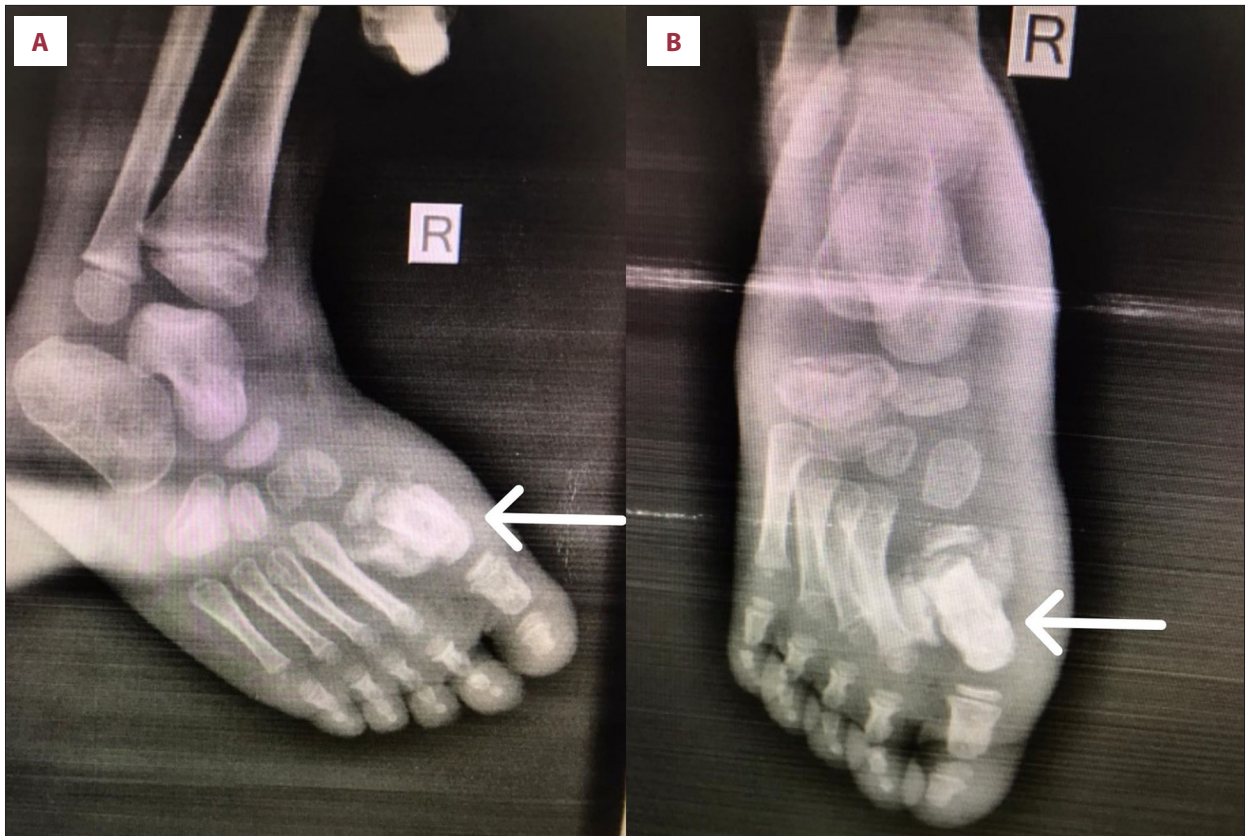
Right foot X-ray, first metatarsal bone fracture, and callous formation (arrow). (A) Lateral view X-ray of the right foot. (B) Anterior-posterior view X-ray of the right foot.
